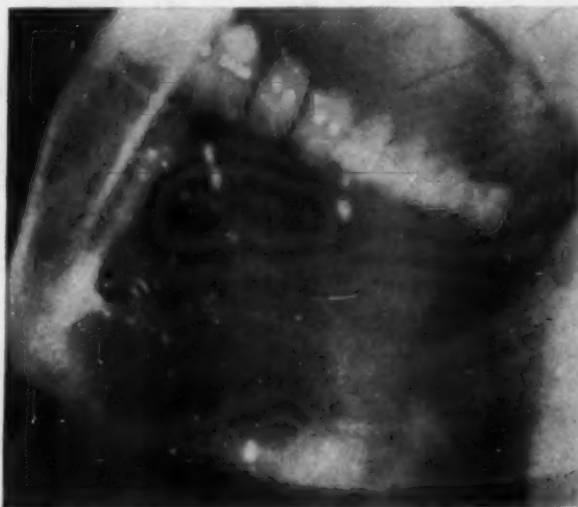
X-ray showing a new giant-cell tumor which had developed on the right side of the mandible.
